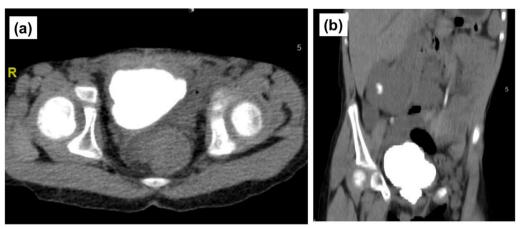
Follow-up CT cystogram after 3 weeks of conservative management showing healed perforation and absence of extravasation: a axial view, b coronal view
